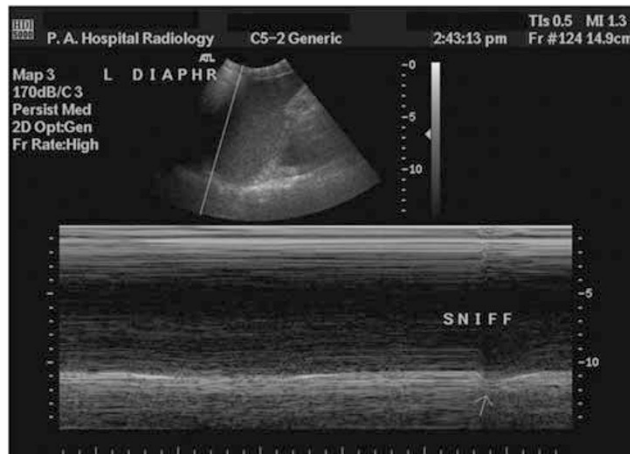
M mode ultrasound trace of paralyzed diaphragm. In a paralyzed diaphragm, there is paradoxical (ie cranial) or absent movement when the patient sniffs
